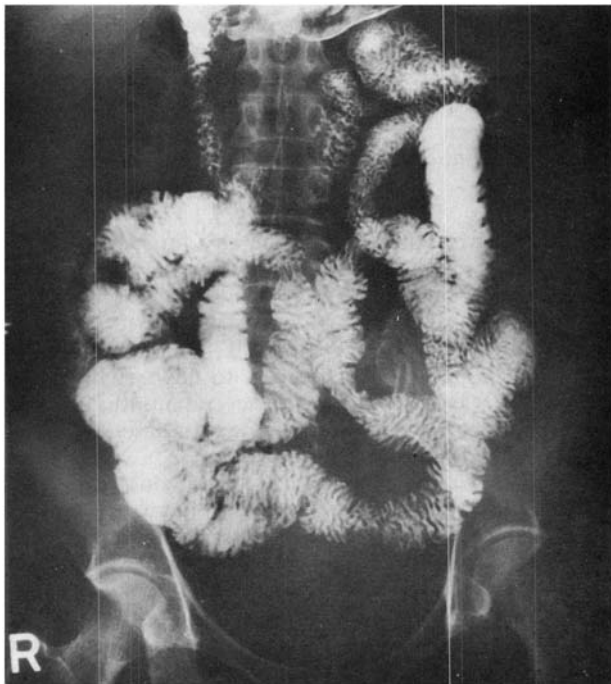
(Case 1.) Barium small bowel X-ray at 30 min. Following three years of effective treatment of the leprosy, the tracing is now within normal limits. (30 April 1971.)
